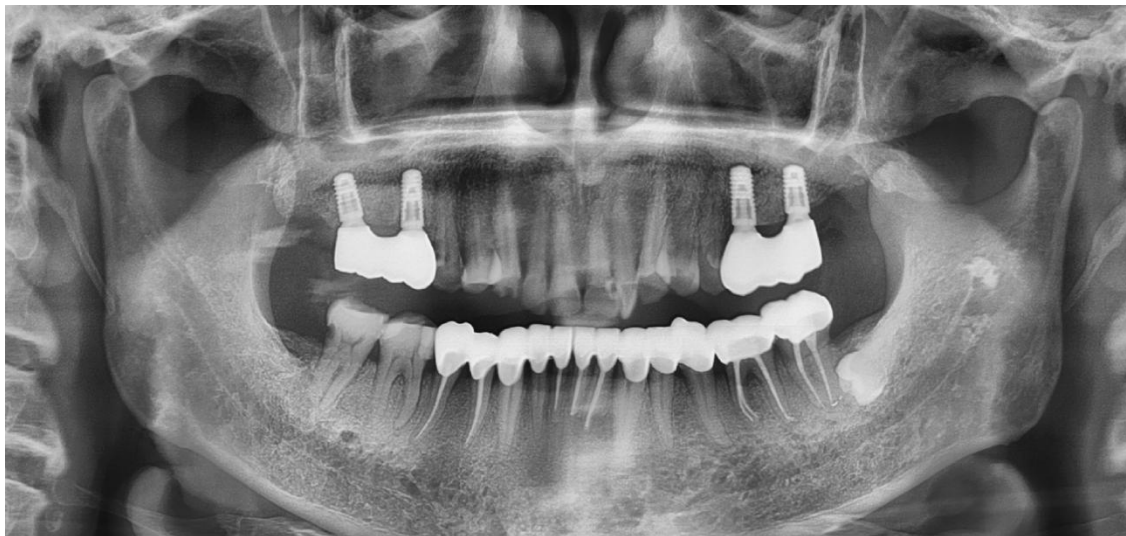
Radiographic follow-up at one month post-surgery
